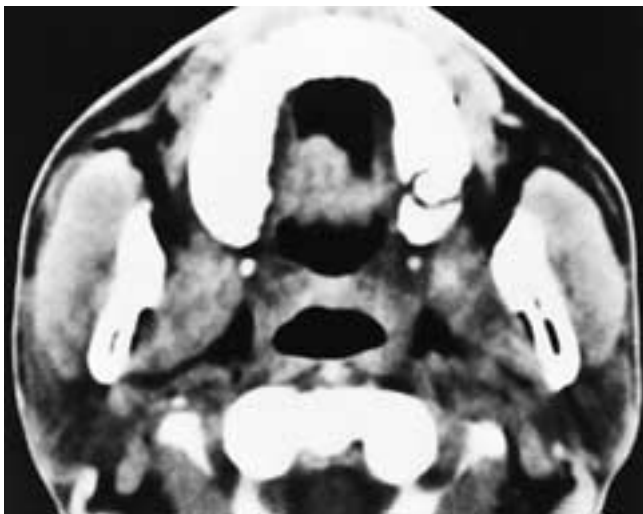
Axial CT scan shows moderate enlargement of the right masseter muscle and possibly the right internal pterygoid muscle. This patient had hypertrophy of the right masticator muscles.
